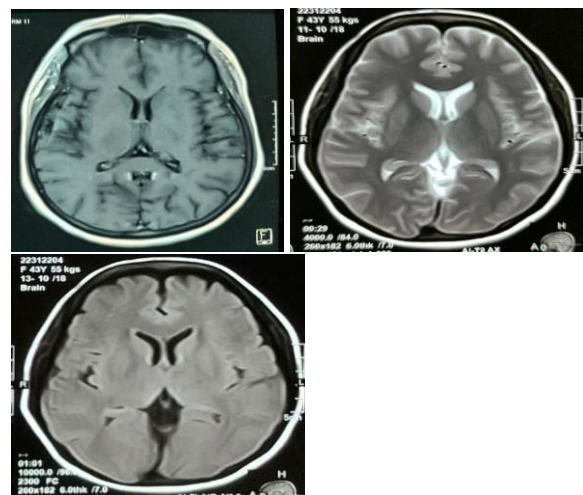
T1,T2, FLAIR sequences of MRI showing no significant abnormality of the basal ganglia region in the same patient (before Radiotherapy).
